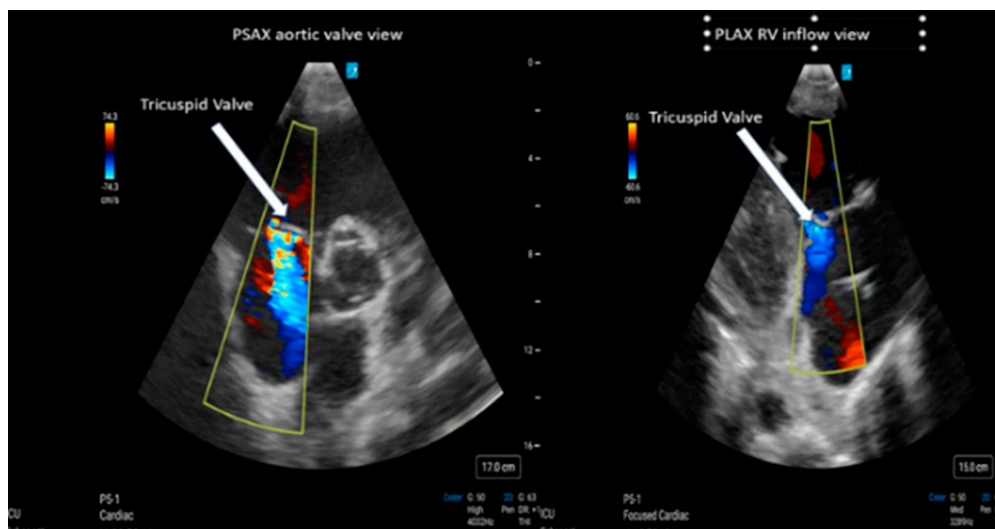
E-learning showing tricuspid regurgitation in the parasternal short axis view and right ventricular inflow view. PLAX = parasternal long axis; PSAX = parasternal short axis; RV = right ventricular.
